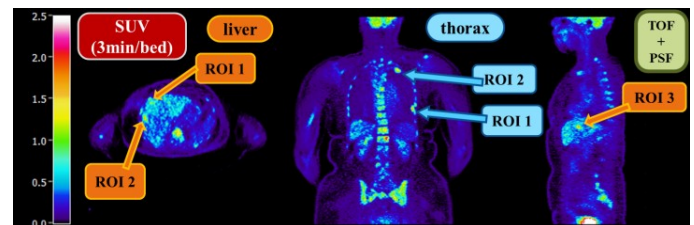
Regions in the liver and thorax evaluated in this study, as drawn from synthesized SUV images after adding all 4 WB passes data acquired between 60-78min [7].
